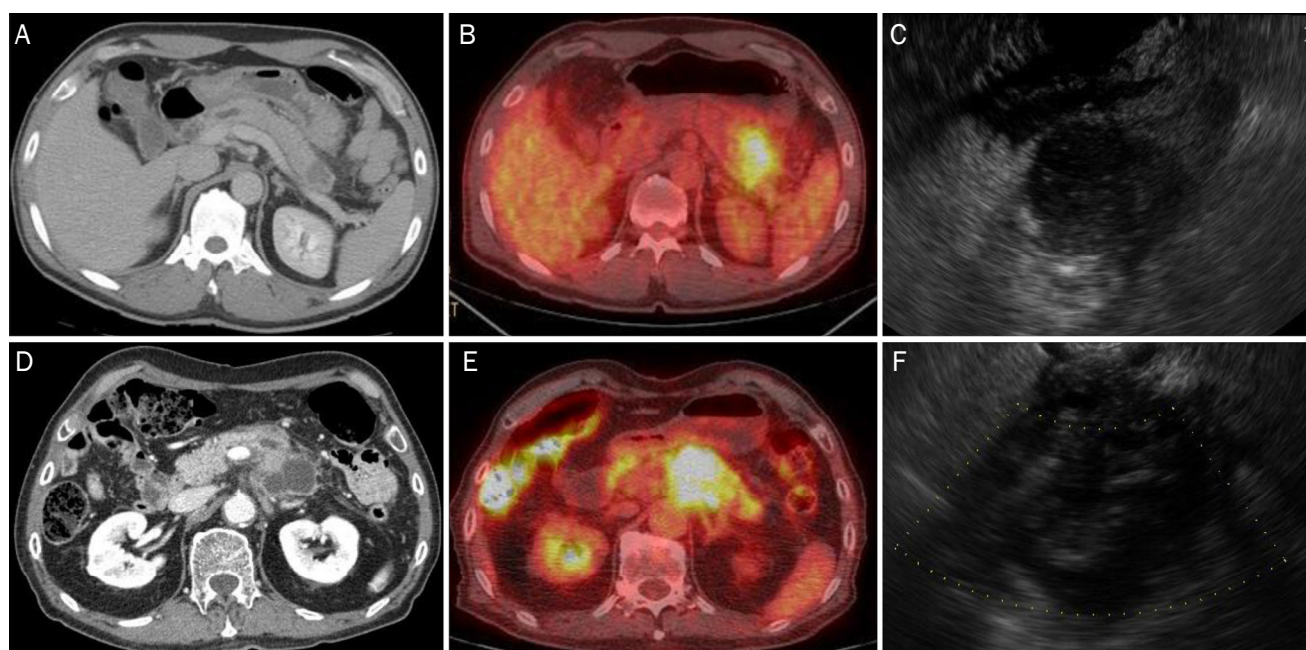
Representative images of a pseudo-tumor (A-C) and pancreatic adenocarcinoma (D-F) in the setting of chronic pancreatitis. (A, D) Abdominal computed tomography scan. (B, E) Positron emission tomography-computed tomography scan. (C, F) Endoscopic ultrasound guided fine needle aspiration.
